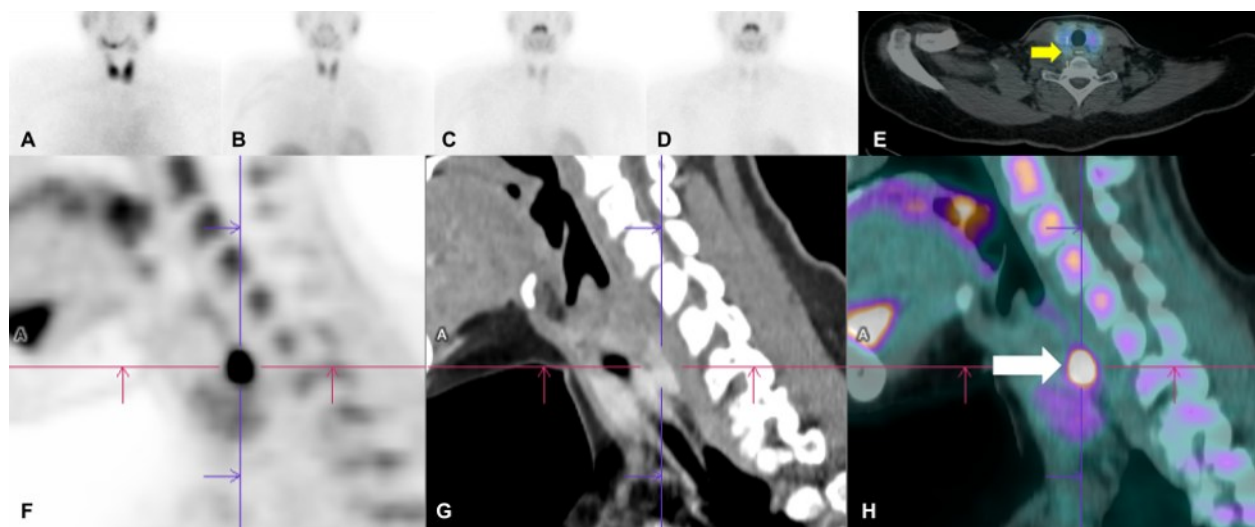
Dual-tracer dual-phase parathyroid scintigraphy showed no pertechnetate-avid (A) and no sestamibi-avid lesion in the initial image 10 minutes after ^{99m}Tc -sestamibi administration (B), as well as in the delayed 2-hour (C) and 4-hour images (D). Axial SPECT-CT image (E) showed a nodular density posterior to the right thyroid lobe with no corresponding sestamibi uptake (yellow arrow). Sagittal PET (F), CT (G) and fused PET/CT (H) images of the neck showed an FCH-avid enhancing nodular focus inferoposterior to the right thyroid lobe (white arrow) measuring 0.8 x 0.9 x 1.2 cm and with a standard uptake value (SUV) of 19.7, suggestive of a parathyroid adenoma.
